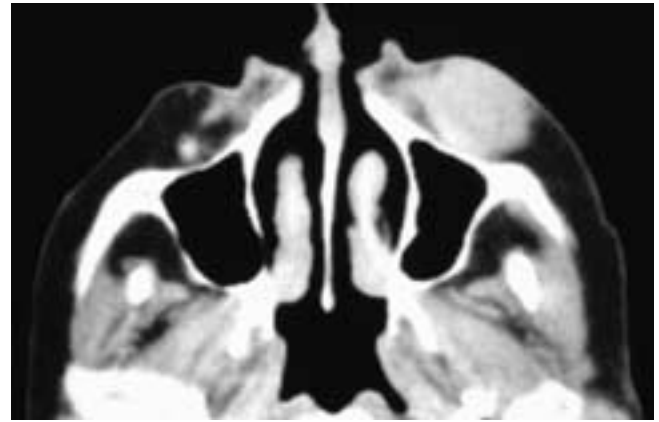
Axial CT scan shows a soft-tissue mass in the subcutaneous tissues of the left face. Portions of the contour of the lesion are unsharp, suggesting focal infiltration. This patient had a Merkel cell tumor.
